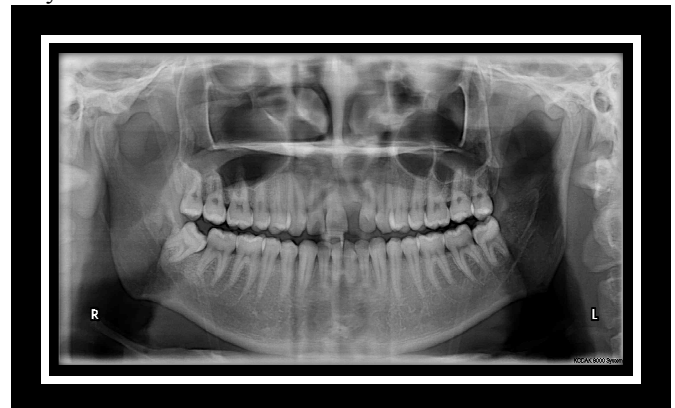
Panoramic radiograph showing right mandibular angle fracture associated with presence of third molar.
